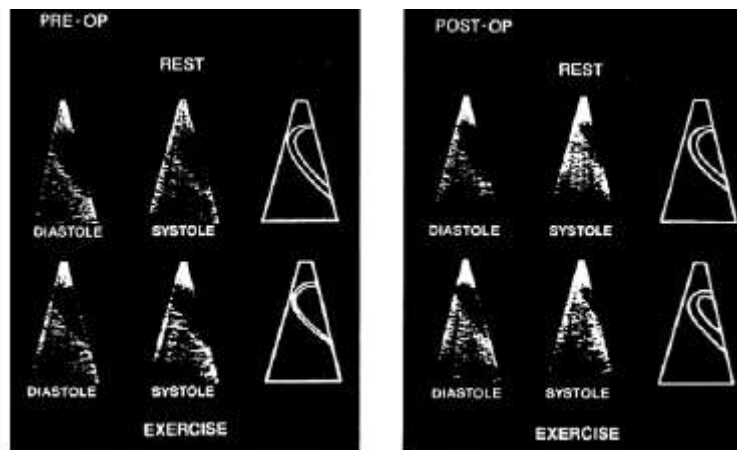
Early two-dimensional stress echocardiogram using 30-degree scanner. Rest and stress images demonstrate apical dyskinesia at time of bicycle exercise (*left*) and resolution of exercise-induced ischemia after successful coronary artery bypass surgery (*right*). (*Wann et al.,1979*).
